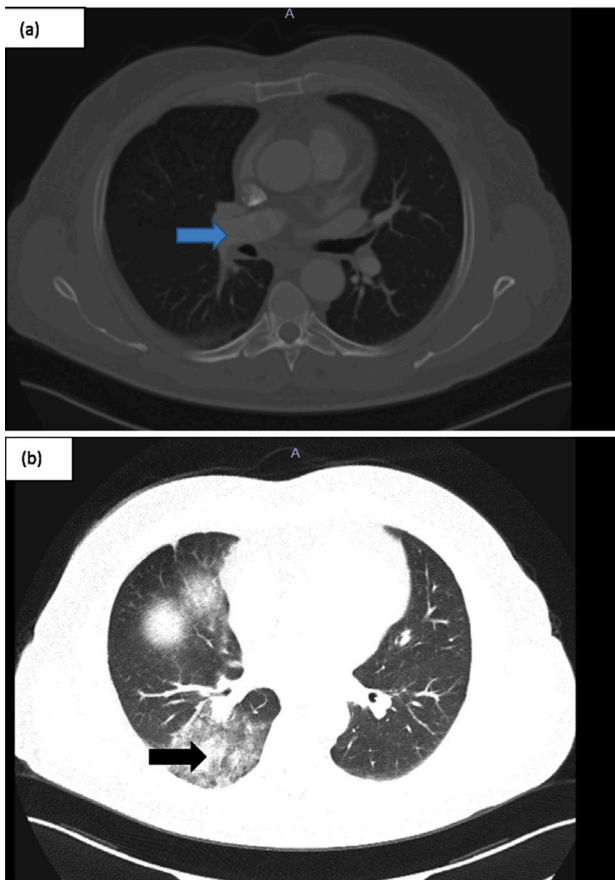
(a) Thoracic computed tomography (CT) showing an aneurysmal enlargement in the right lower lobe pulmonary artery with thrombus inside (blue arrow) (b) ground glass opacity representing a pulmonary hemorrhage (black arrow)
